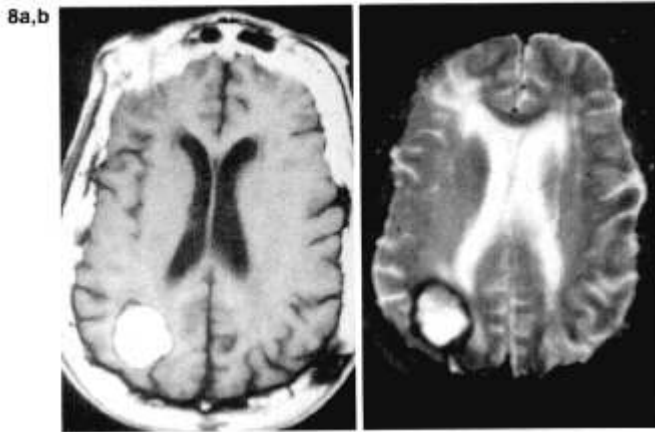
Three week right posterior hemispheric hematoma at 1.5 T. a: T1-weighted image (TR 600/TE 15 ms) shows hyperintensity due to continued presence of methemoglobin. b: T2-weighted image (TR 2,500/TE 80 ms) is hyperintense as in Fig. 5c. Thin surrounding dark band is due to hemosiderin/ferritin laden macrophages. A slight dark band from hemosiderin/ferritin can also be seen in (a). Right frontal lobe changes are of ischemic nature.
